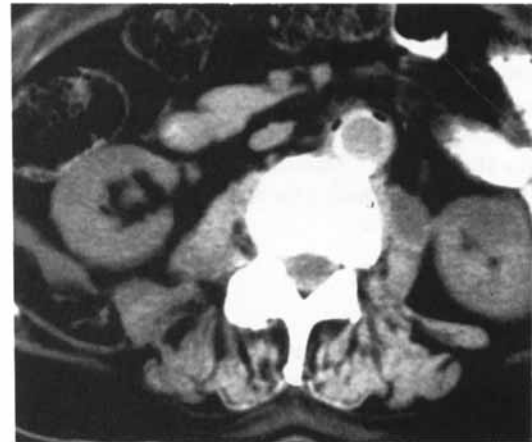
Computed tomography scan. Gas is seen between the graft and the remaining aneurysmal layer.
